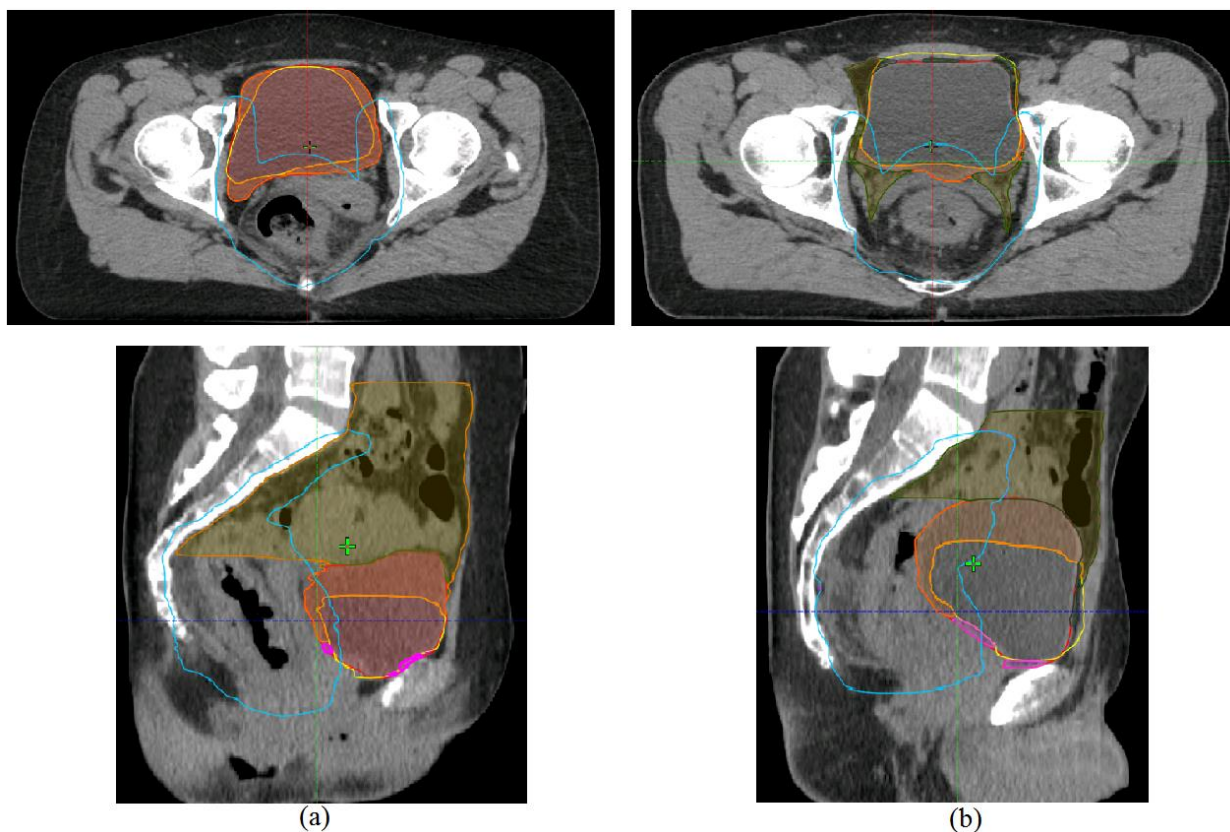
Axial and sagittal frames of the planning CT image of (a) patient 7 and (b) patient 11. Blue = PTV-T plus PTV-E., dark green = $rBowel$ (CT), red = bladder (CT), orange = $rBowel$ (CBCT fraction 11), yellow = bladder (CBCT fraction 11), pink = excluded part of $rBowel$ (CBCT fraction 11) after post processing.
